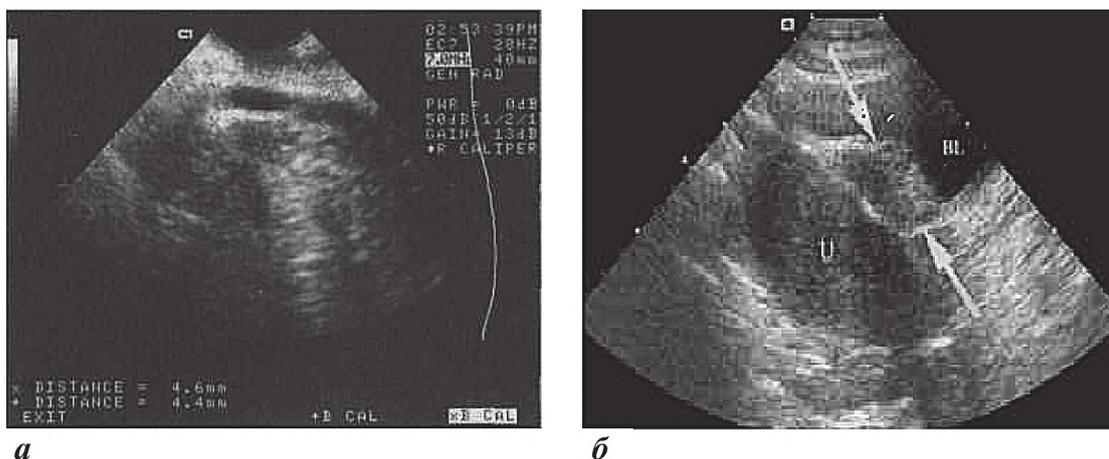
(a; b) – Ultrasound. Structural changes of the endometrium and myometrium in patients with endometriosis on ultrasound (own observation)
